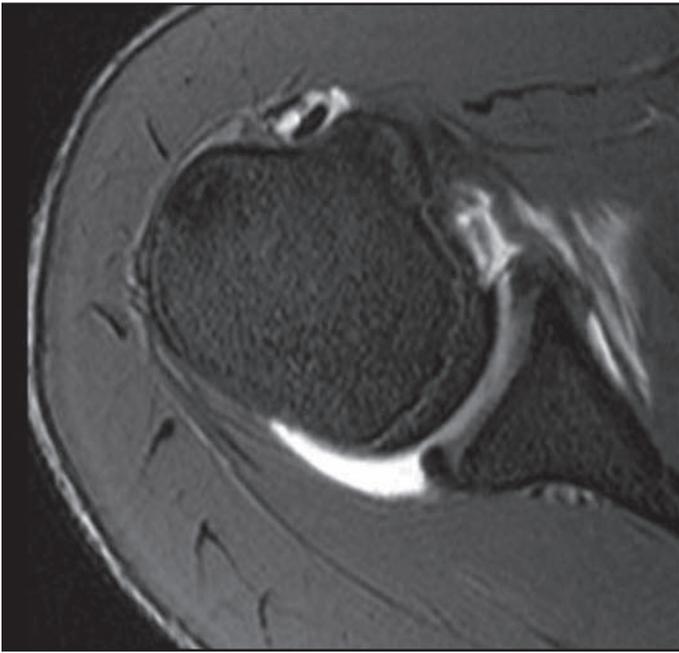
An axial view MRI revealing disruption of the humeral attachment of the glenohumeral ligament.
